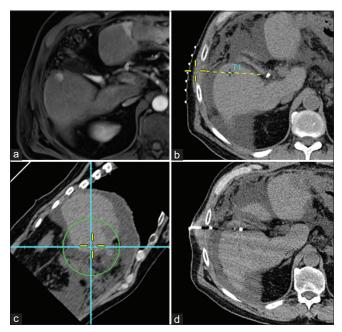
A 69-year-old female with cryptogenic cirrhosis found to have LIRADS-5 lesion in hepatic segment V. (a) Axial magnetic resonance imaging T1 post-contrast sequence shows a 1.2 cm enhancing target lesion with trajectory planning. (b and c) 3D computed tomography (CT)-US needle navigation (PercuNav, Philips, Andover, MA) images show. (d) Axial non-contrast CT demonstrates an microwave ablation antenna placed through a lateral percutaneous approach. The antenna was placed through the axis of the tumor.
